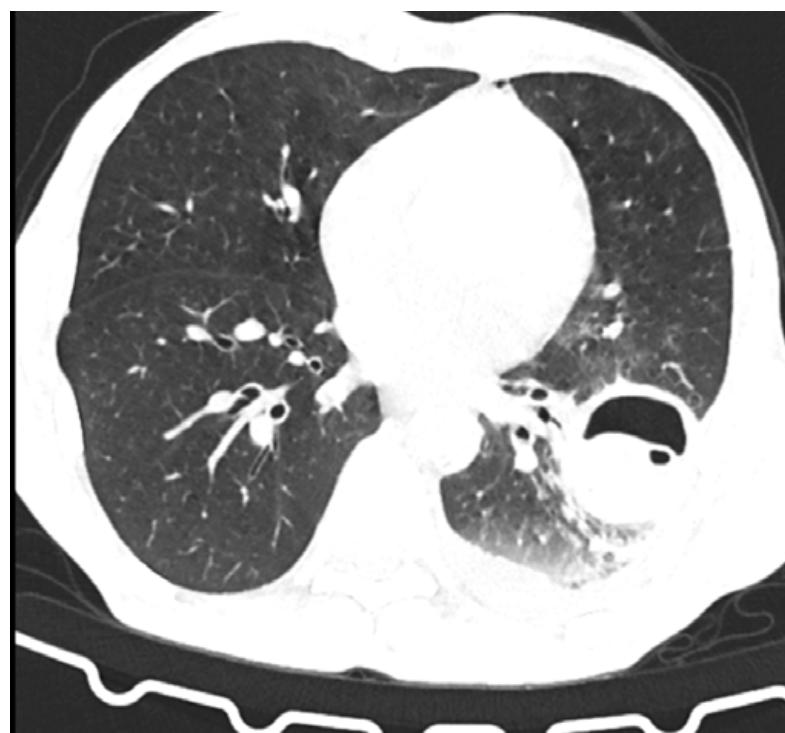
Chest CT scan of a patient with a cyst cavity in the posterobasal segment of the left lower lobe adhered to the lateral chest wall with loculation in the cyst and air-fluid level (perforated hydatid cyst) (Case Two).
